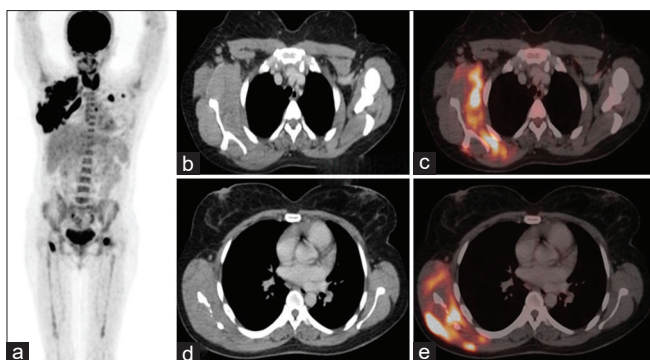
Maximum-intensity projection image (a), demonstrating fluorodeoxyglucose-avid lesions in the muscles, bones, thyroid gland, and diffusely increased fluorodeoxyglucose uptake in the bone marrow. Axial computed tomography (b) showing mass-like enlargement of the right subscapularis muscle and fused positron emission tomography/computed tomography (c) showing fluorodeoxyglucose-avid lesions in the right subscapularis muscle along with lytic changes in the scapula. Axial computed tomography (d) showing mass – slightly bulky right infraspinatus muscle and fused positron emission tomography/computed tomography (e) showing fluorodeoxyglucose-avid lesions in the right infraspinatus muscle
